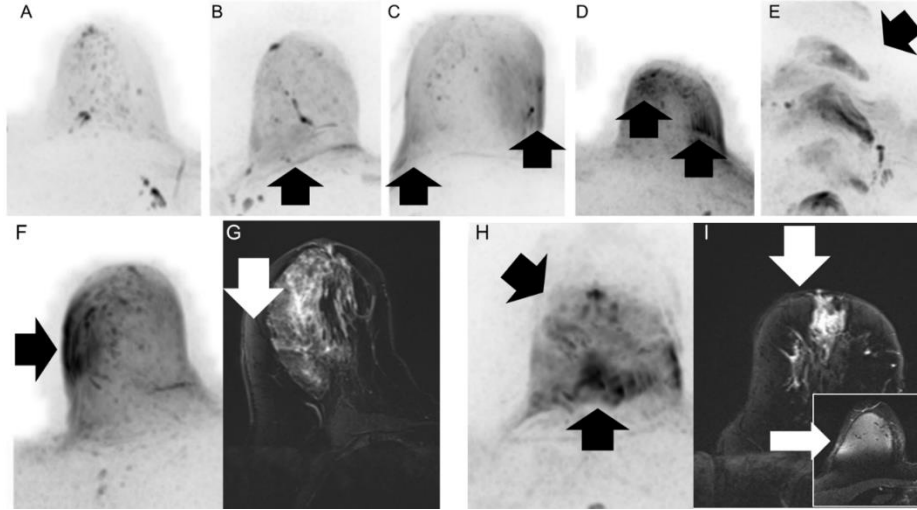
A-E: Examples of artifacts in the different classes: A = no artifacts, B=minimal artifacts, C=moderate artifacts, D= pronounced artifacts, E=highly significant artifacts (black arrows mark the artifacts). F/G: Pronounced artifact in the high b-value DWI MIP (F, 1500s/mm²) (black arrow) with corresponding subtle signal intensity increase in the T2-weighted fat saturated image (G, white arrow). H/I: Highly significant artifacts in the high b-value DWI MIP (1500s/mm²) (black arrows) with corresponding (rather subtle) blurry appearance in the T2-weighted fat saturated image (I) and a locally inhomogeneity in the fat saturation in a skin fold underneath the breast (small image and small arrow).
